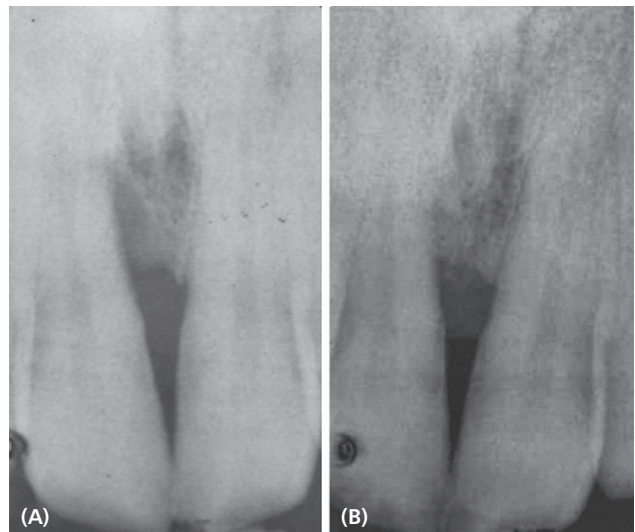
A. Initial periapical radiograph of tooth 8 showing the vertical intrabony defect on the mesial surface. B. Periapical radiograph of tooth 8 at five-month re-evaluation visit showing bone fill on the mesial surface.
